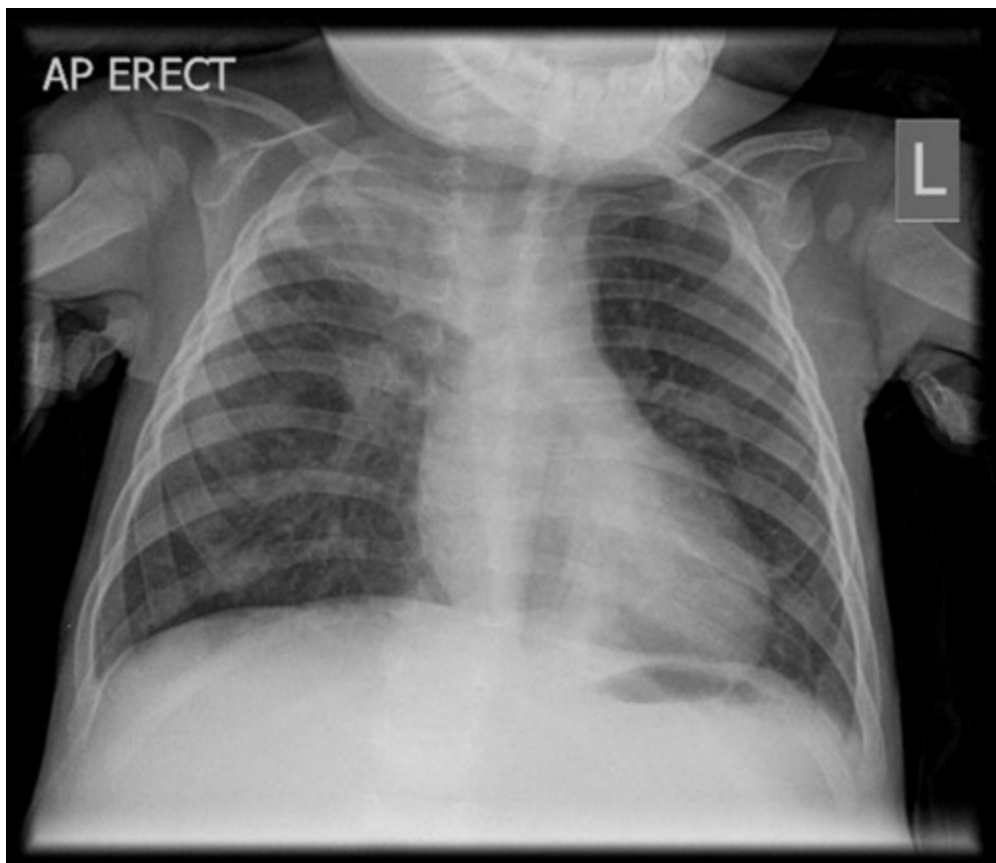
Chest X-ray obtained on admission. [↩](#)
